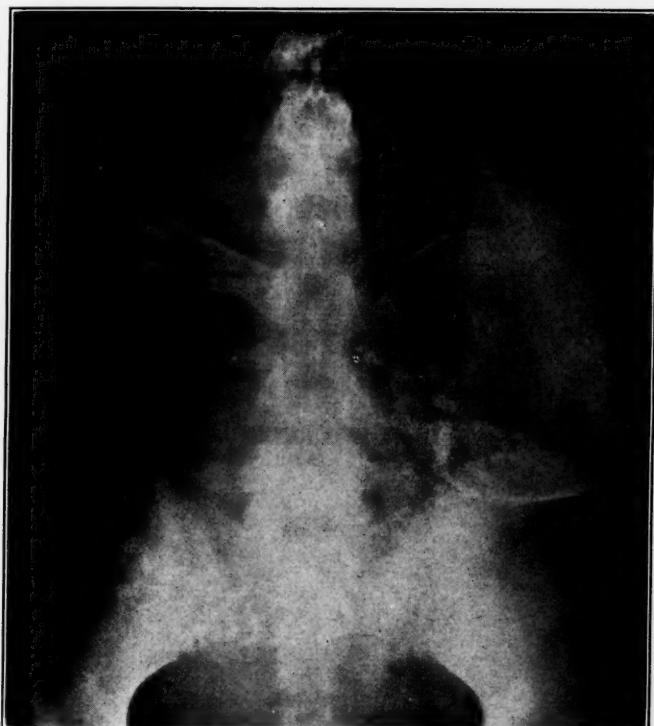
Photograph of x-ray taken July 26, 1938.
